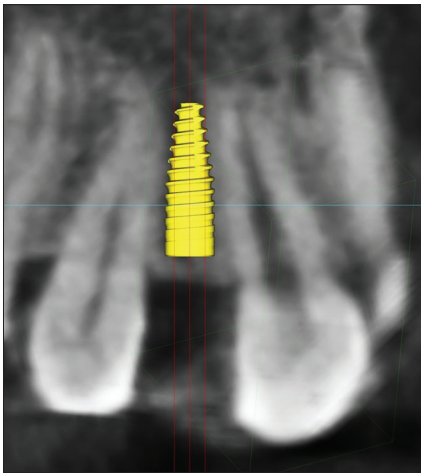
Sagittal cone-beam computed tomography view of the space available for the insertion of the implant in site 12
